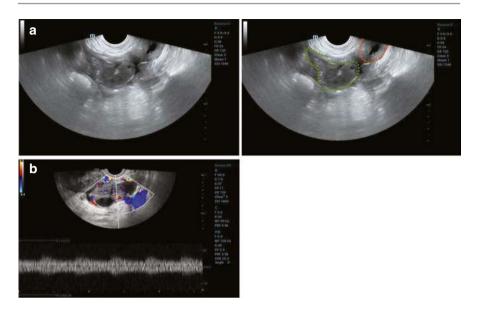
(a) Ultrasound image showing a mass adjacent to the uterus with irregular alignment and a hypoechoic interior, surrounded by multiple hyperechogenic spots. The mass is circled in green; the uterus is outlined in orange. (b) Color Doppler ultrasound shows rich blood flow signals within the mass
